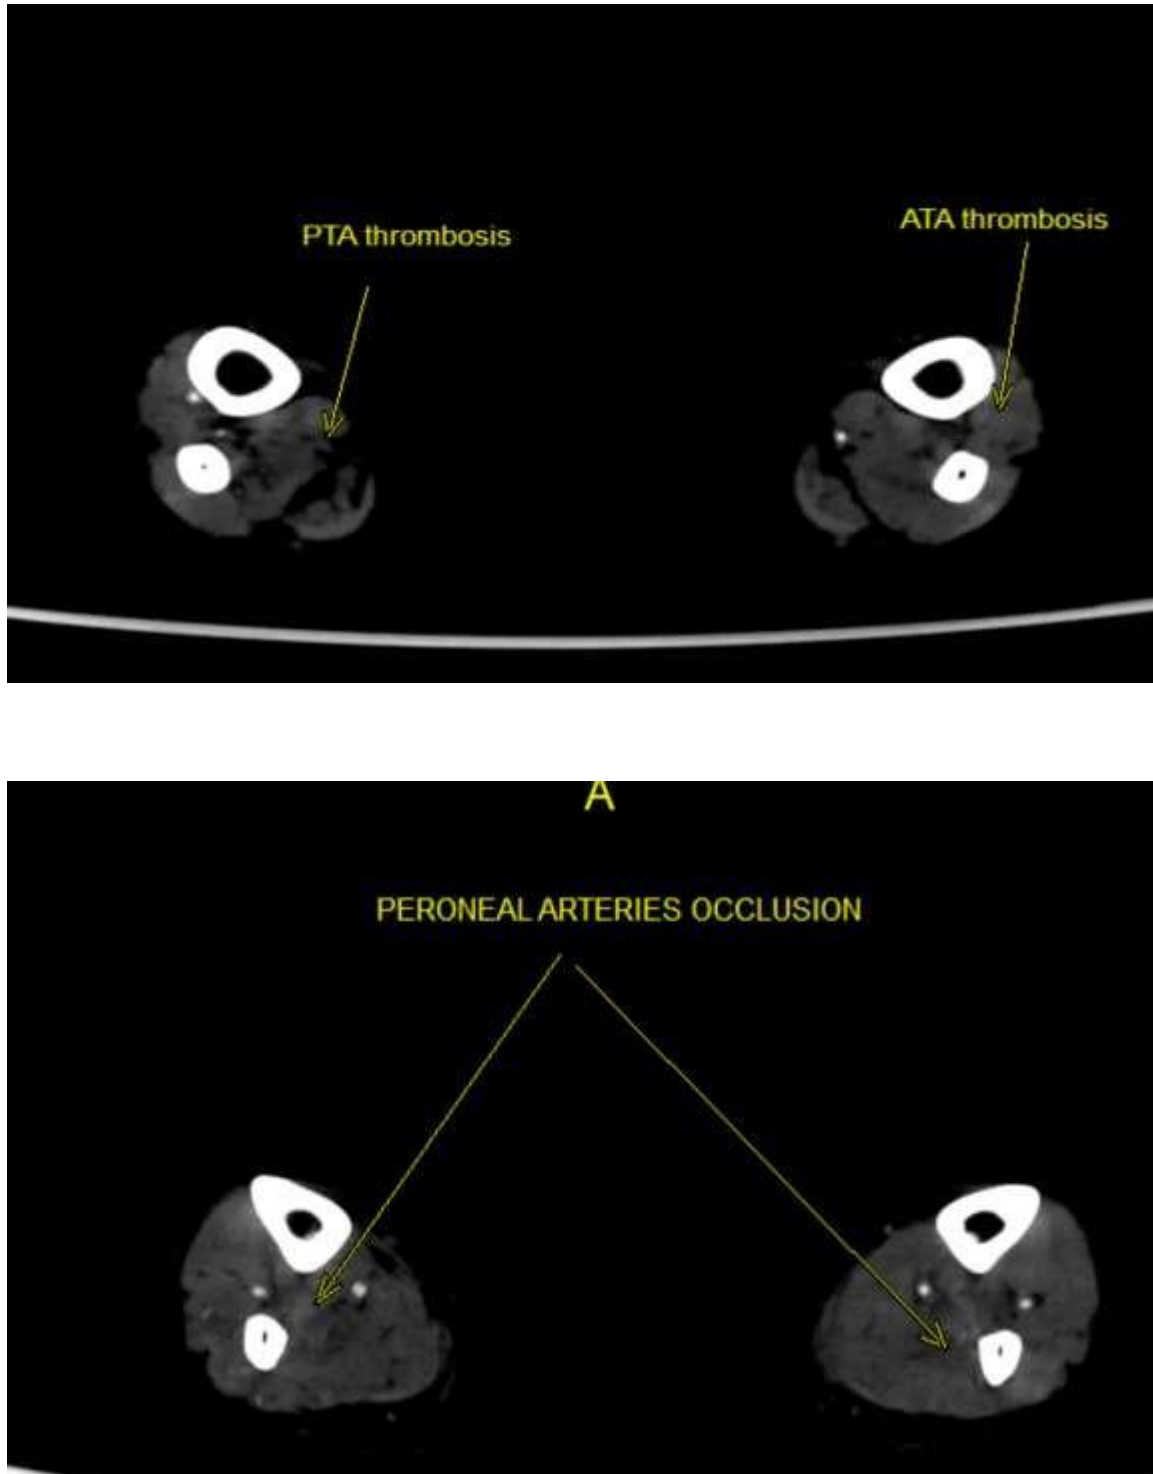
CT LOWER LIMB ANGIOGRAM (AXIAL) OF A COVID-19 PATIENT SHOWING THROMBOSIS OF THE LOWER LIMB TIBIO-PERONEAL ARTERIES.
